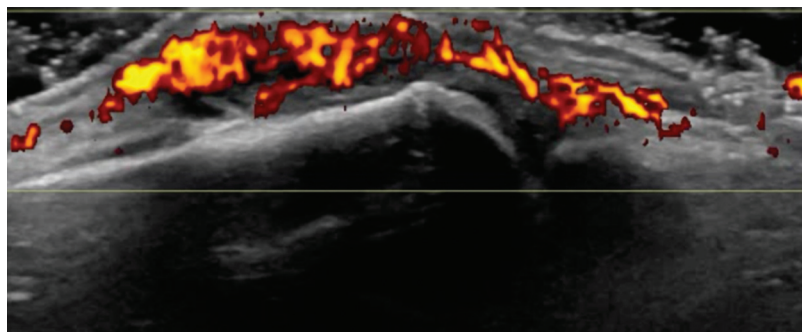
Synovitis with intense Doppler signal in an acute inflammatory episode of gout in second metacarpophalangeal joint.
